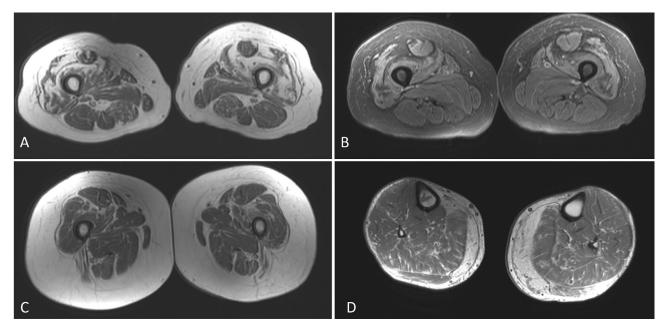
Lower Limb Muscle Magnetic Resonance Imaging in Inclusion Body Myositis.
